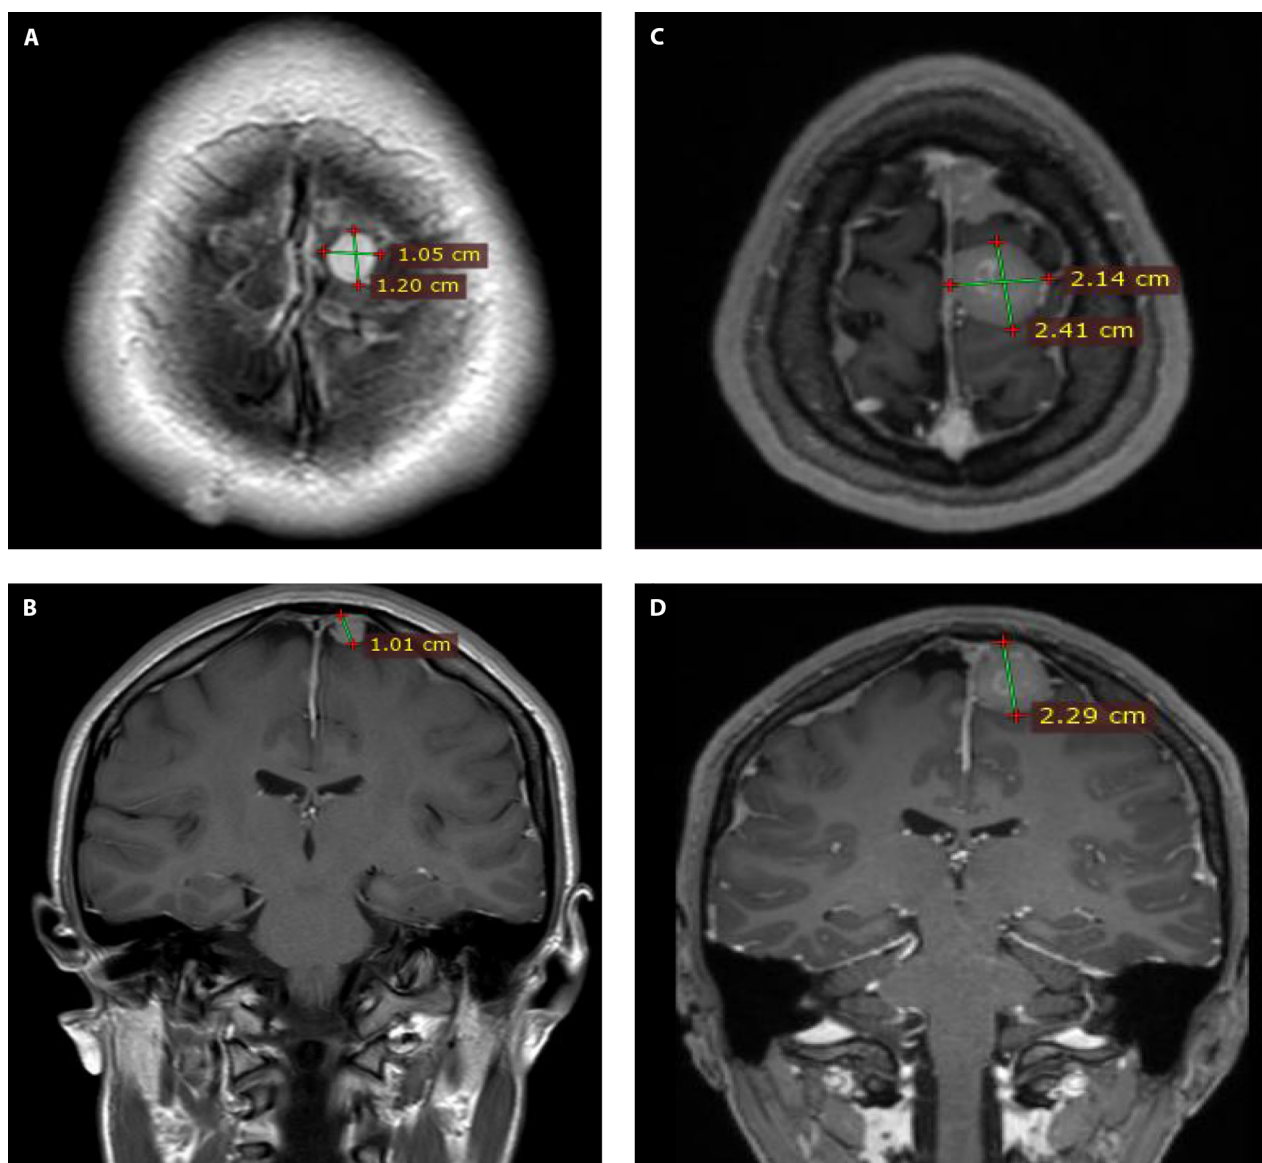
A comparison of axial and coronal T1 C+ (Gd) MRI scans from 2019 (A, B) to 2023 (C, D) indicated the enlargement of the most prominent meningioma located in the left frontal region, which measured measuring 12x10x10 (APxLLxCC) in the 2019 and 23x22x21 mm in the 2023.
